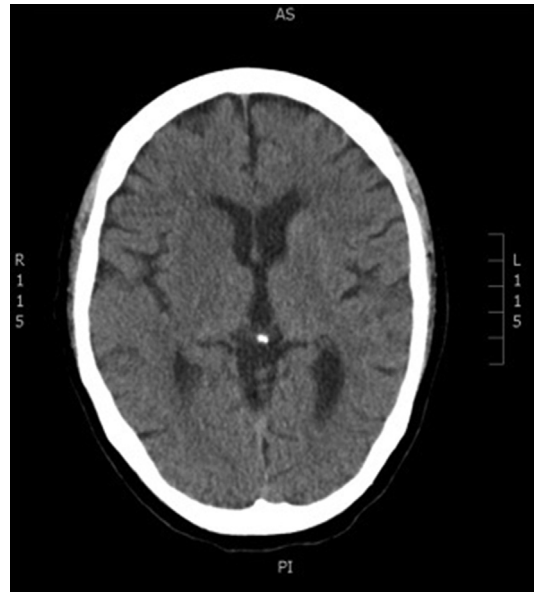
CT of the head on presentation of the patient in case 1 shows no abnormalities.
